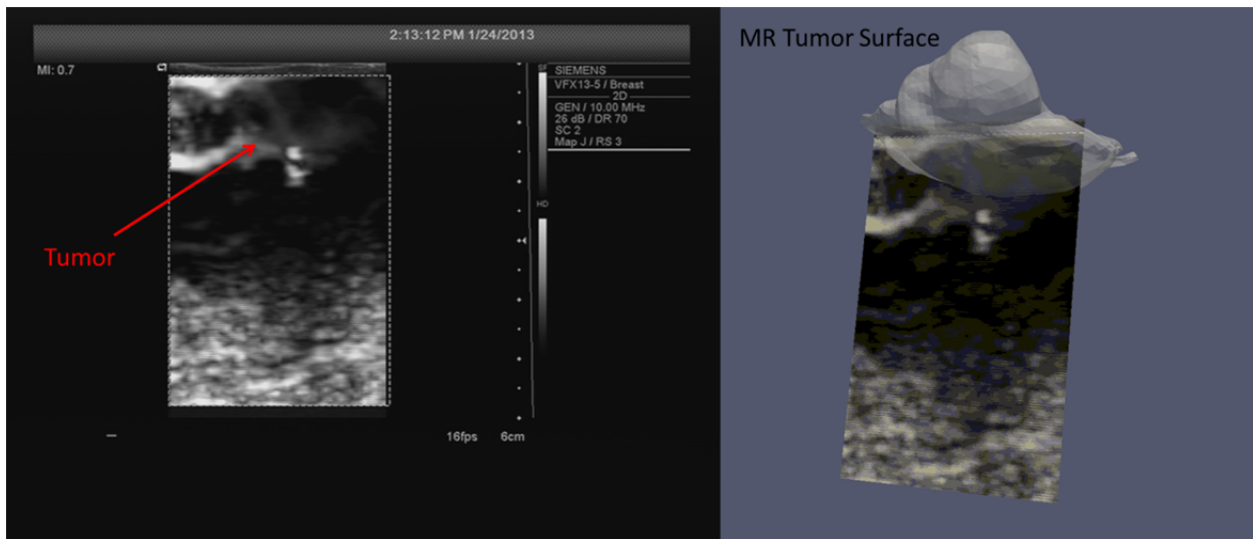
A strain image of the brain tumor (left), and the tracked ultrasound image in 3D space with the co-registered MR tumor (right).
